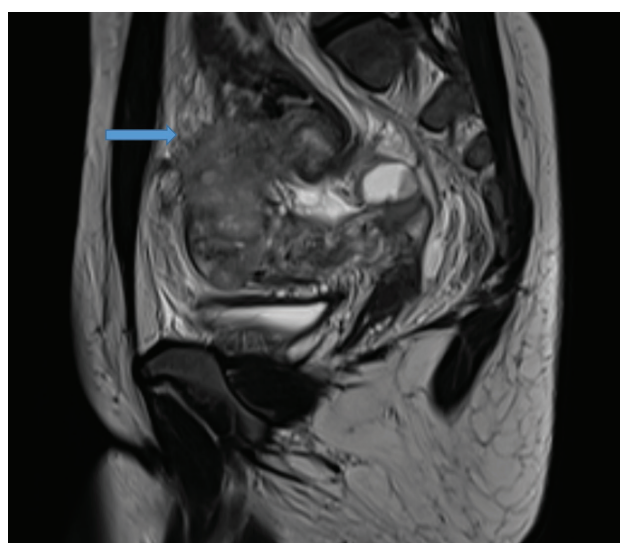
MRI T2 Sagittal sequence- Dermoid passed, but fistula into the sigmoid evident as shown by the blue arrow.
